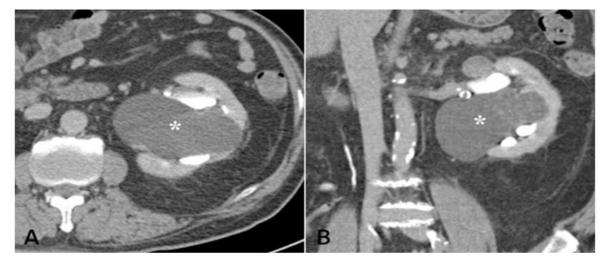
Contrast-enhanced axial (a) and coronal (b) CT images taken in the renal excretory phase show a large left parapelvic cyst (asterisk) and associated hydronephrosis.
